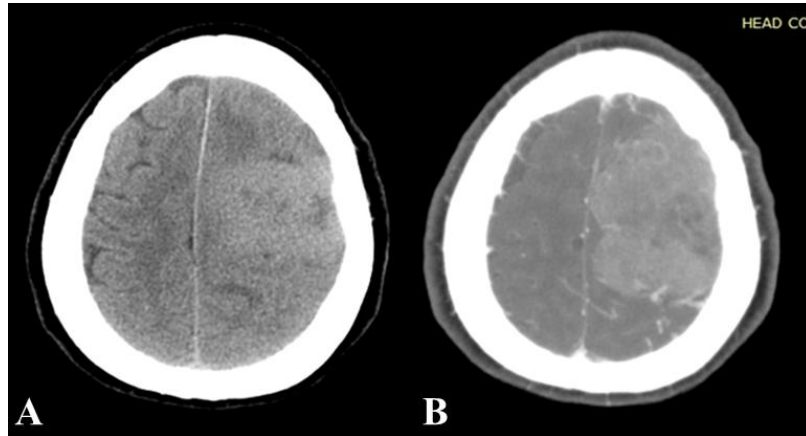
CT image of convexity meningeoma:
